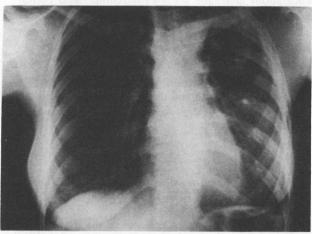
Chest X-ray of 38-year-old female. A) Myxedema heart and protein-bound iodine (PBI) value of 1.1 microgram/100 ml. B) Normal-sized heart, six months after thyroid replacement therapy.
